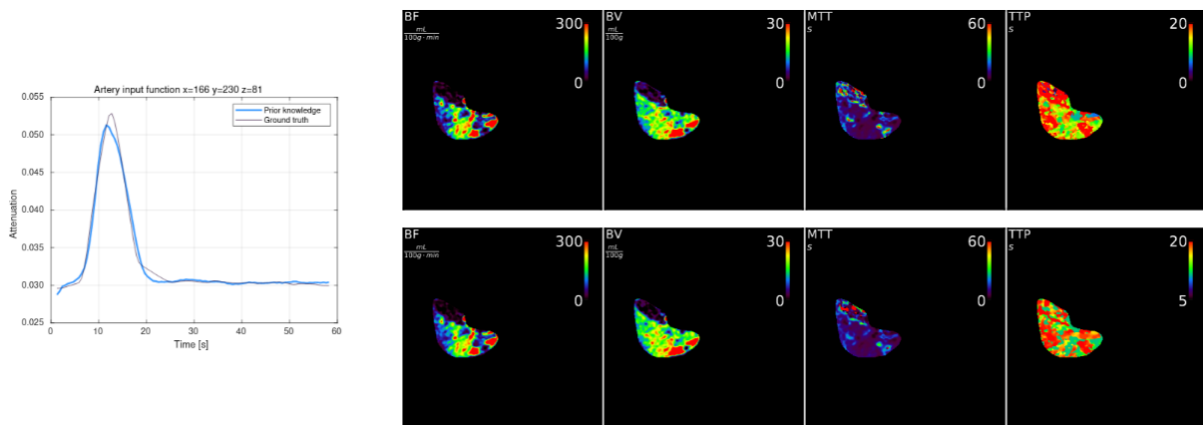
Artery input function and perfusion maps. Second row are perfusion maps generated by fitting prior knowledge to CT reconstructions.
